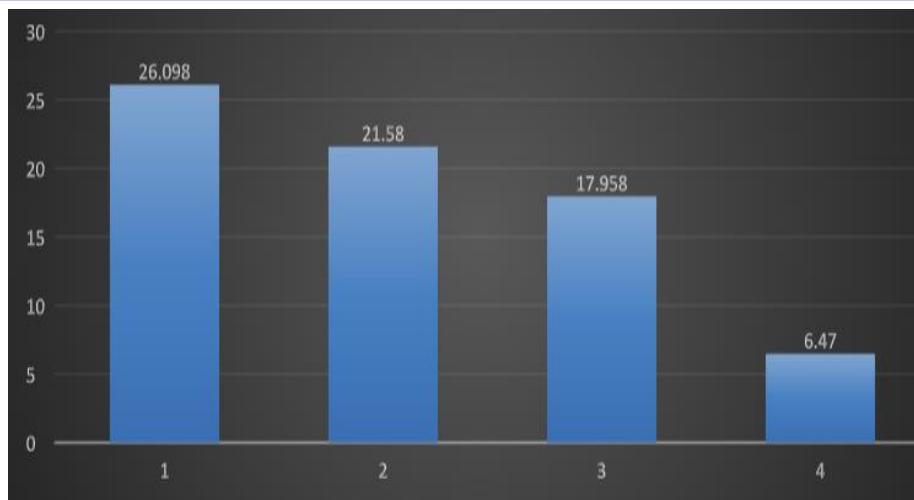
Mean push-out bond strength values for the tested groups at different root canal locations. 1-MTA Bioputty (middle 3rd) 2-MTA Bioputty (apical 3rd) 3-Ultrasonically condensed gutta percha (middle 3rd) 4-Ultrasonically condensed gutta percha (apical 3rd)
